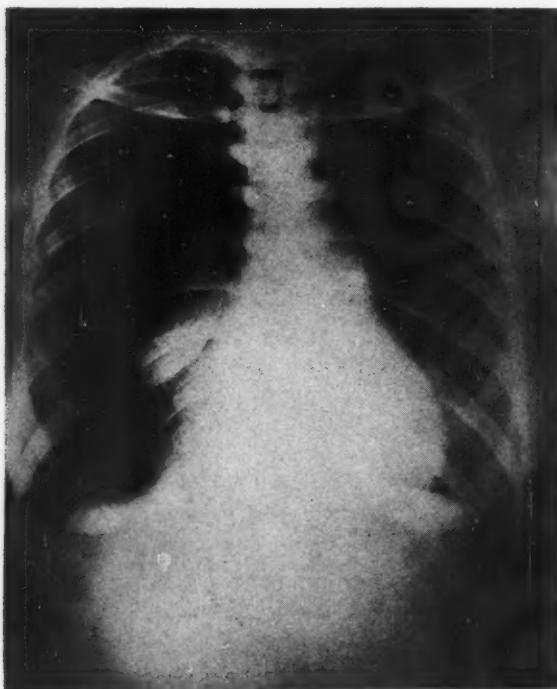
Chest roentgenogram on third admission showing complete right pneumothorax.
